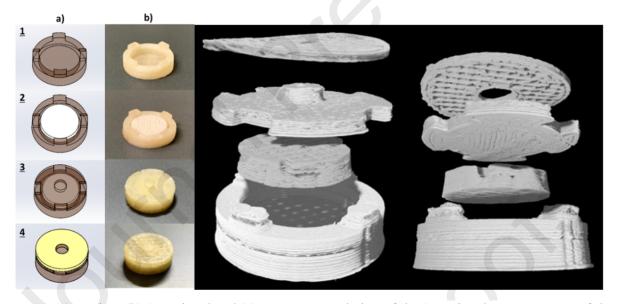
(a) Design, (b) 3D printed and (c) X-ray CT rendering of the 3D printed compartments of the solid dosage form. From left to right, bottom compartment of the placebo section, top compartment of the placebo section, caffeine compartment and Melatonin compartment. Reprinted with permission from (Ghanizadeh Tabriz et al., 2023).
